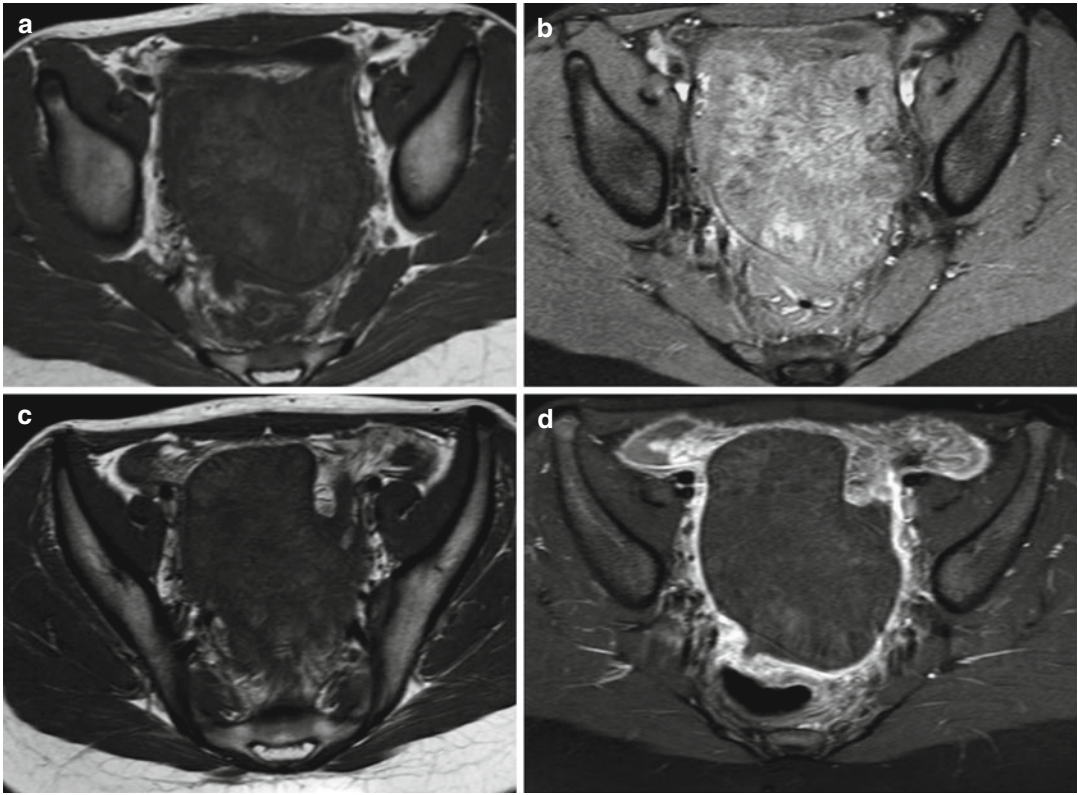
Twisted right ovary in a 14-year-old girl with 1 week of abdominal pain. Axial T1-weighted (a) and axial T1-weighted fat-saturated MRI (b) show an enlarged medialized diffusely hyperintense ovary resulting to a
